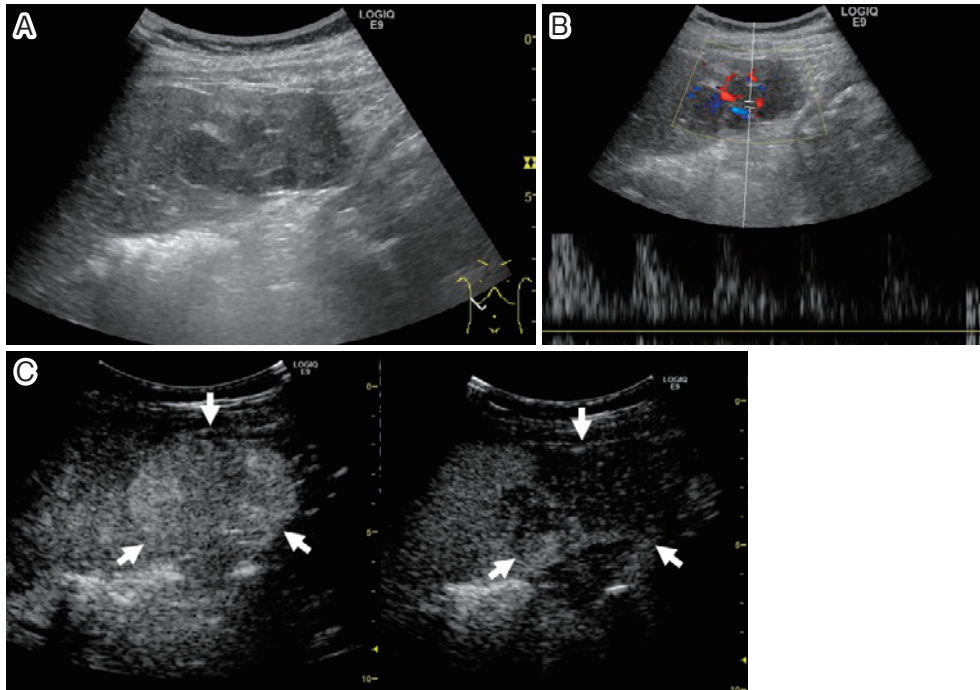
Abdominal ultrasound images
